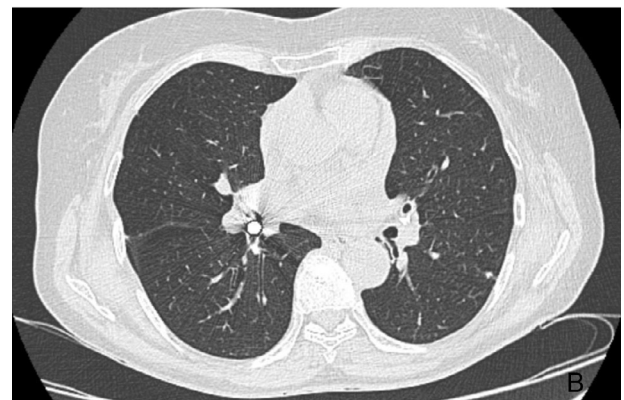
Thoracic CT scan showing the drill head located in the right intermediate and right lower bronchi. (A) coronal view (B) axial view.
